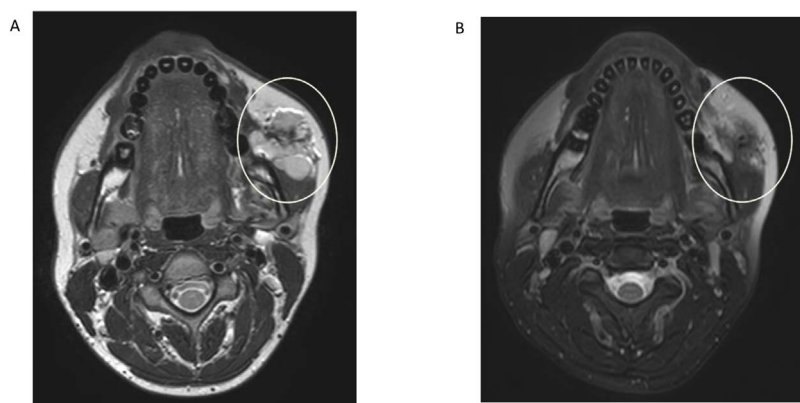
T2-weighted axial MRI demonstrating a subfascial intramuscular venous malformation involving the left masseter muscle of a 26 year old female. Large hyperintense VM before therapeutic management (A). Decreased signal intensity and massive size reduction after two percutaneous sclerotherapies (B).
